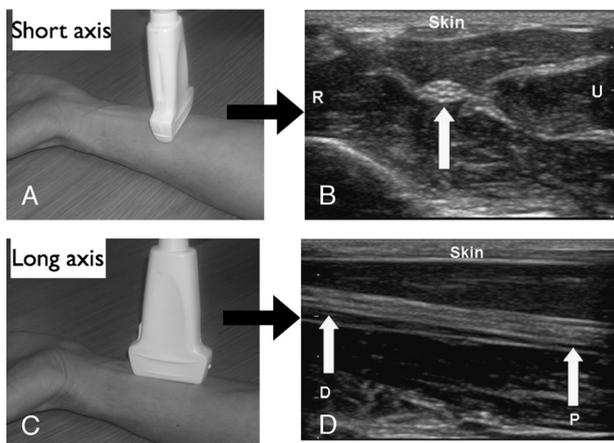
Ultrasound terminology for describing non-needle-related structures. Figure 1A and 2B demonstrate the short-axis (transverse) imaging of the median nerve in the forearm. When the transducer is turned 90 degrees in either a clockwise or counterclockwise direction, the long-axis (longitudinal) view is generated. The long-axis view is represented in Figure 1C and 1D. The arrows in Figure 1B and 1D indicate the median nerve. R, radial side of the arm; U, ulnar side of the arm; D, distal part of the nerve; P, proximal part of the nerve.
